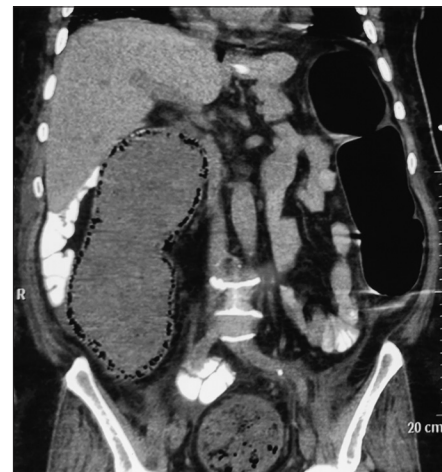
Non-contrast CT scan of abdomen revealed marked distention of cecum, ascending, and transverse colon, with intramural bowel gas within cecum, ascending, and transverse colon (pneumatosis intestinalis).
